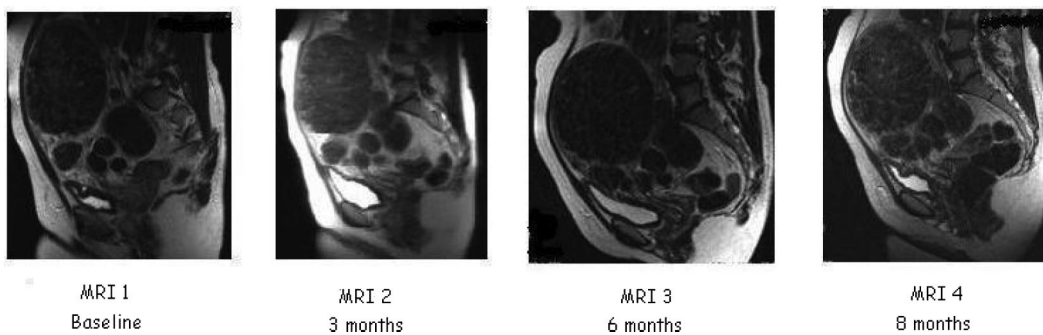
Abdominal MRI scan of a study participant taken at four time points.
